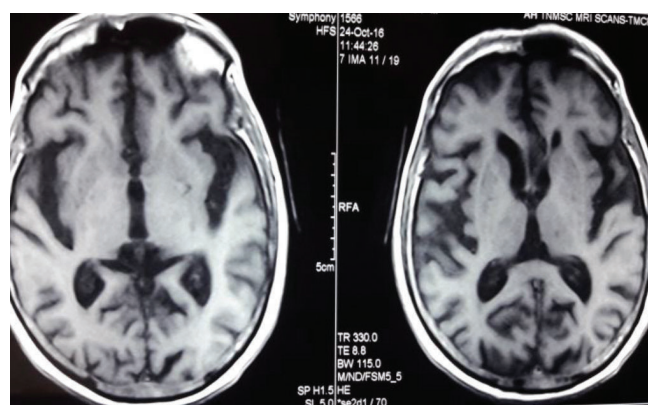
An 84 years old male presented to us 2 episodes of generalised tonic clonic seizures. On MRI there was global cerebral atrophy, ventricular dilatation and chronic bifrontal infarcts. Figure showing T1 Weighted images showing Cerebral Atrophy as denoted by prominent cerebral sulci and ventricular dilatation
